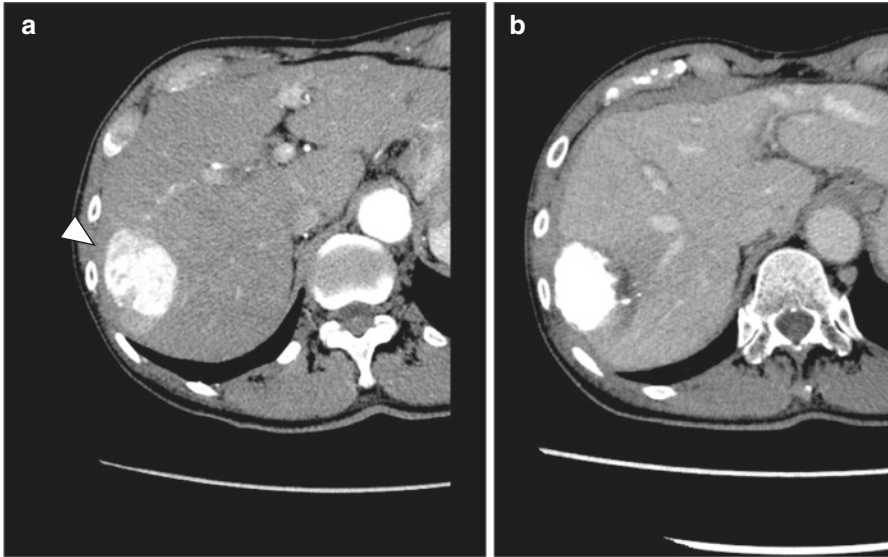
A case with 5 cm HCC treated with TACE + RFA. (a) An arterial phase of dynamic CT shows hypervascular tumor in segment 7. (b) The tumor was treated with TACE + RFA. A dense lipiodol deposit was surrounded by un-enhanced area indicating ablative margin
